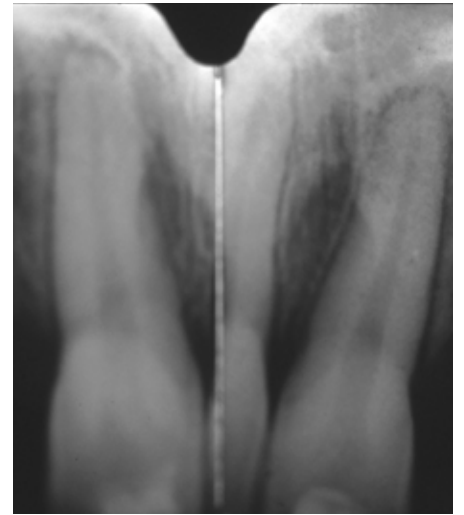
Radiograph taken in the initial phase of the orthodontic treatment.
